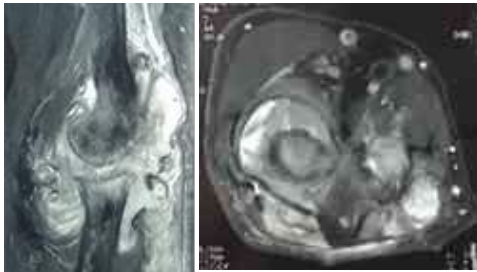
MRI Elbow with contrast. The sun ray appearance suggesting to primary bone tumor malignant
